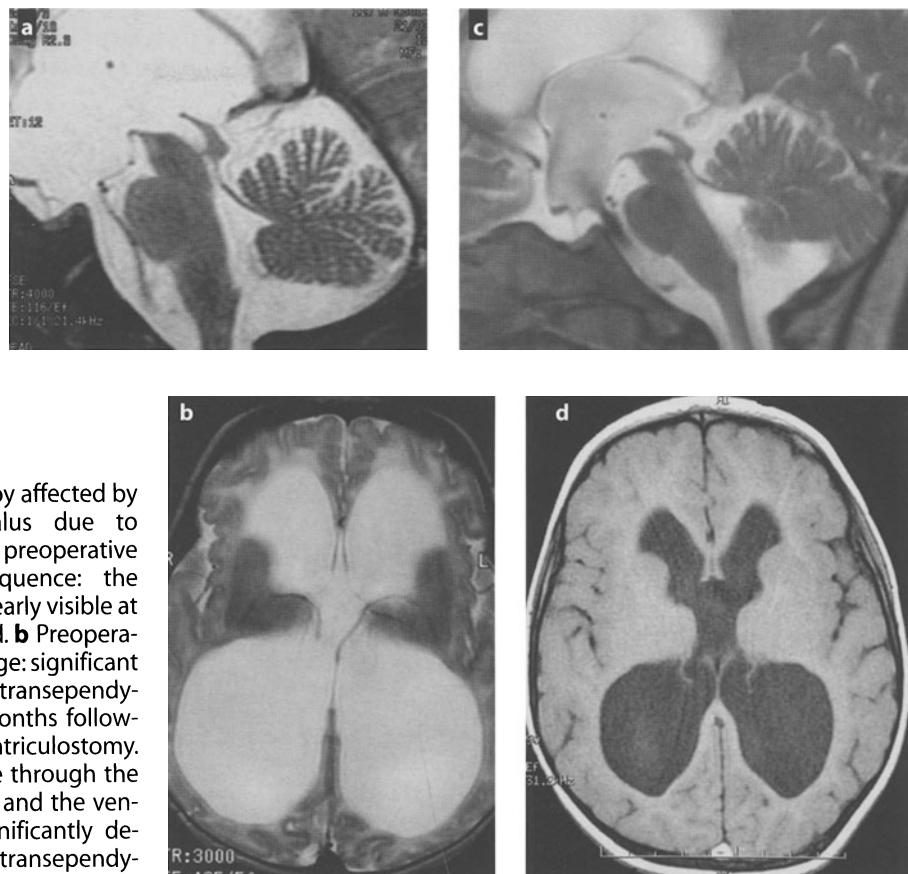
One-year-old boy affected by triventricular hydrocephalus due to aqueductal stenosis. a MRI, preoperative sagittal T2-weighted sequence: the aqueduct obstruction is clearly visible at the level of the lower third. b Preoperative axial T2-weighted image: significant ventricular dilatation with transependymal resorption. c Three months following endoscopic third ventriculostomy. Flow void artifact is visible through the floor of the third ventricle and the ventricular dilatation has significantly decreased with resolution of transependymal resorption (d)
